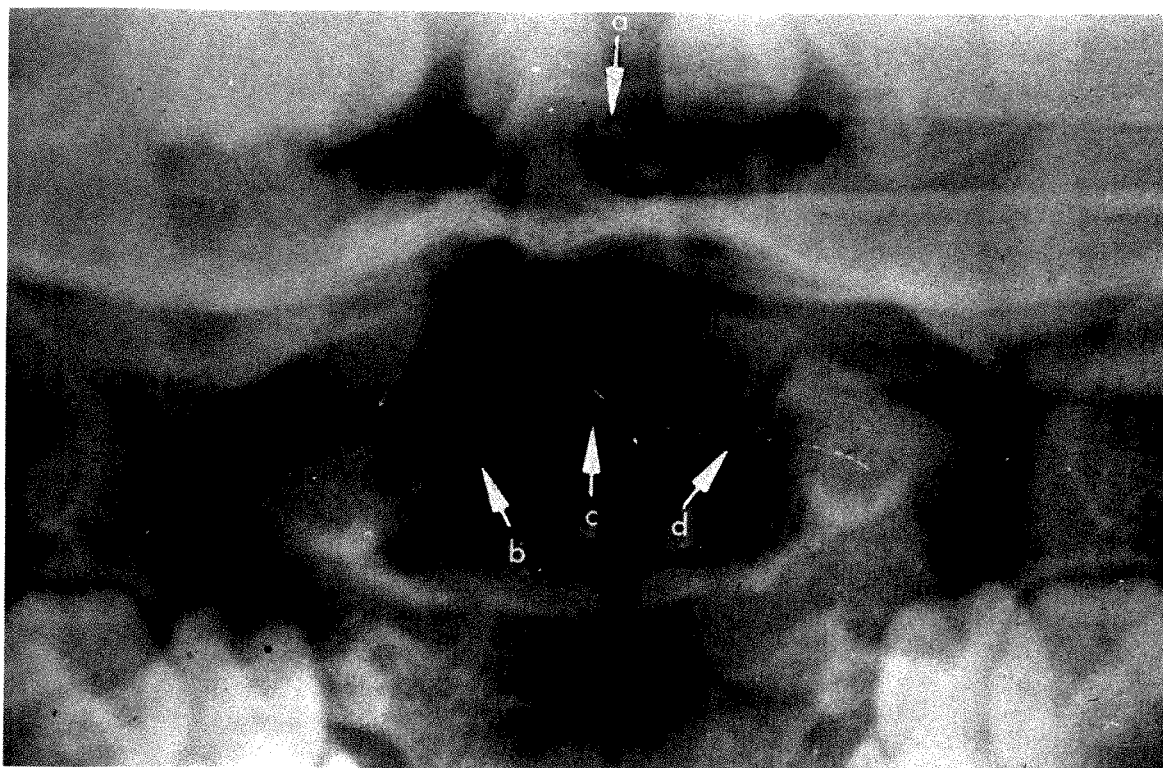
Anteroposterior radiograph at C2 level. *a*, Absence of fusion of ossification centers of dens. *b*, Dysplasia of superior articular facet of axis on right side due to incomplete ossification of base of dens and anterior part of center of ossification of neural arch. *c*, Junction of base of dens with ossification center of neural arch on left side continuous with subdentate synchondrosis. "Base of dens" participates in buildup of medial part of articular facet. *d*, Cleft at proximal end of dens with center for tip of dens (ossiculum terminale).
